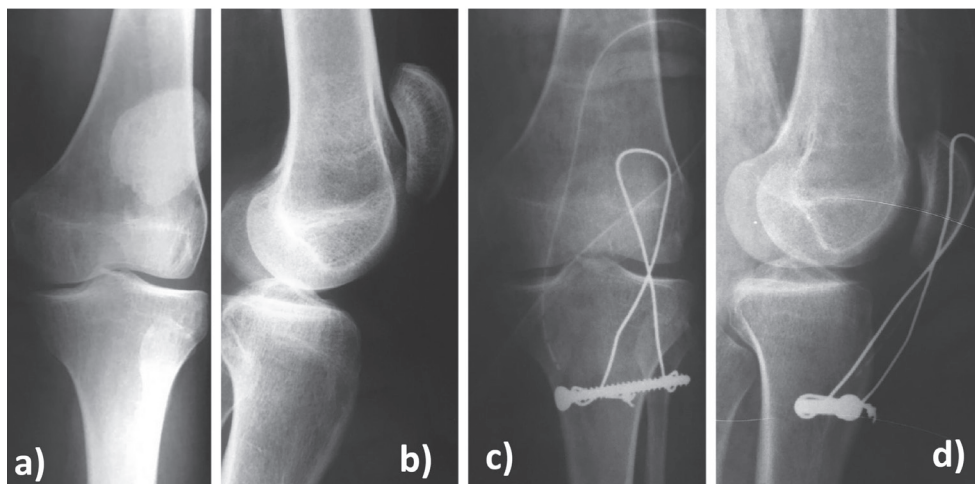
Preoperative weight-bearing anteroposterior (a) and laterolateral (b) radiographs of the left knee. Postoperative anteroposterior (c) and laterolateral (d) radiographs of the left knee.
